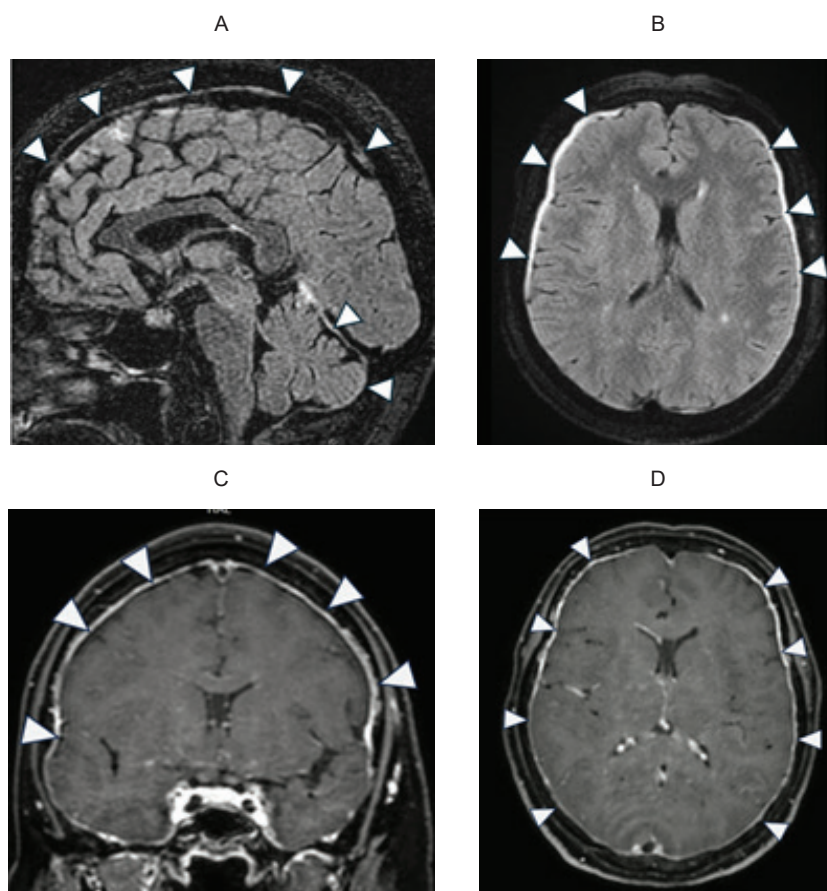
Brain MRI of the patient (2 months after the onset): A (sagittal), B (axial) – FLAIR images showing higher signal from the dura mater and the tentorium of cerebellum; C, D – post-contrast pachymeningeal enhancement. Arrows indicate the corresponding changes in FLAIR images an increase in the signal from the dura mater is determined, mainly in the fronto-parietal regions, and the tentorium of the cerebellum; C, D – contrast enhancement reveals a uniform accumulation of contrast in the meninges and tentorium of the cerebellum. Arrows indicate the corresponding changes.
